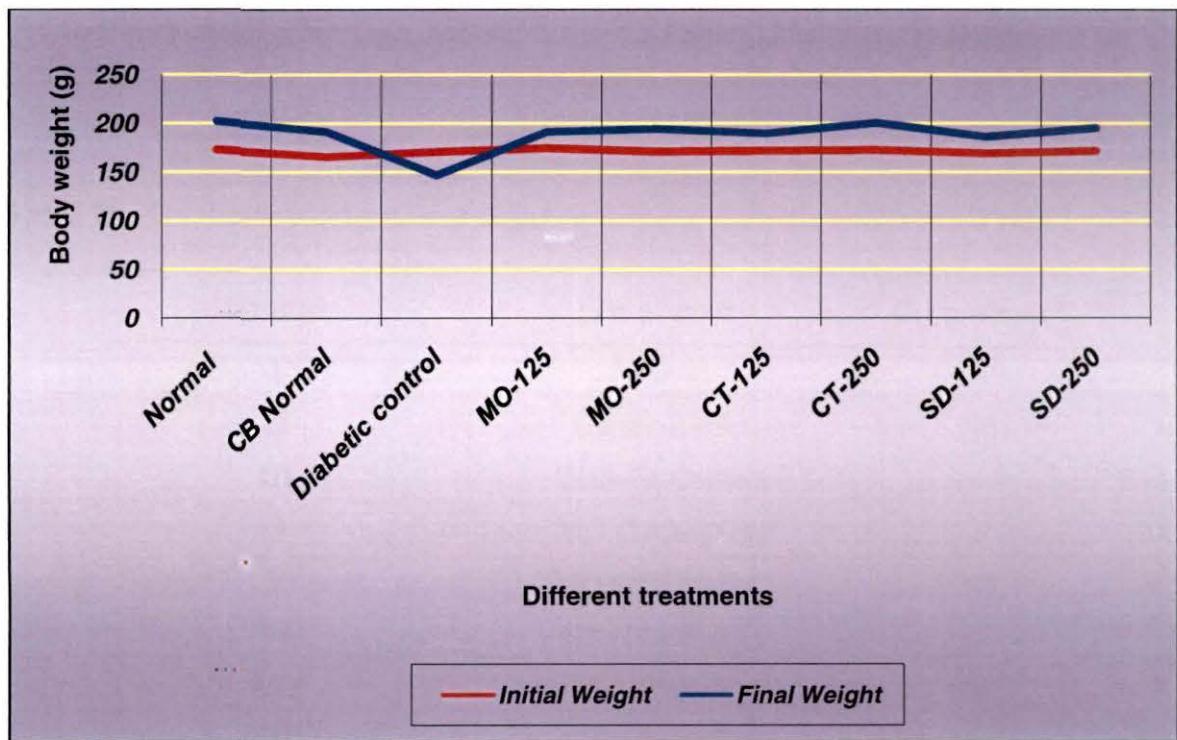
Effect of different extracts on changes in body weight; MO= *Moringa oleifera*, CT= *Cinnamomum tamala*, SD= *Scoparia dulcis*.
